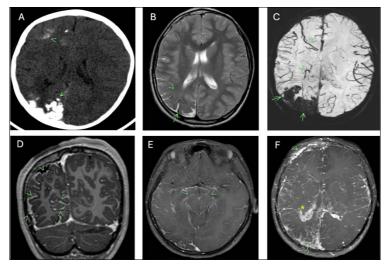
Neuroimaging findings of Sturge-Weber syndrome. (A) Axial non-contrast CT head demonstrated right cerebral atrophy and characteristic tram-track calcifications in the right parieto-occipital and frontal regions, involving both gyral and subcortical areas(arrowheads). (B) Axial T2-weighted demonstrates diffuse right cerebral hemispheric atrophy (arrow) with abnormal white matter signal hyperintensity (arrowhead) in the right parieto-occipital region, suggesting dysmyelination or gliosis. (C) Susceptibility-weighted imaging (SWI) confirmed extensive calcification appearing as areas of marked signal dropout in the right parieto-occipital region (arrow). Note is made of prominent medullary and deep draining veins in the right cerebral hemisphere (arrowhead). Post-contrast T1-weighted images in the coronal plane (D) and axial plane (E) demonstrated extensive leptomeningeal enhancement over the right cerebral hemisphere, particularly prominent in the parieto-occipital region (arrowheads). Bilateral midbrain and pons pial enhancement was noted (arrowheads). (F) Axial post-contrast T1-weighted MIP images demonstrate extensive leptomeningeal enhancement over the right cerebral hemisphere. Additionally, the right choroid plexus is enlarged and shows enhancement. There is a small scalp hemangioma in the right frontal region.
